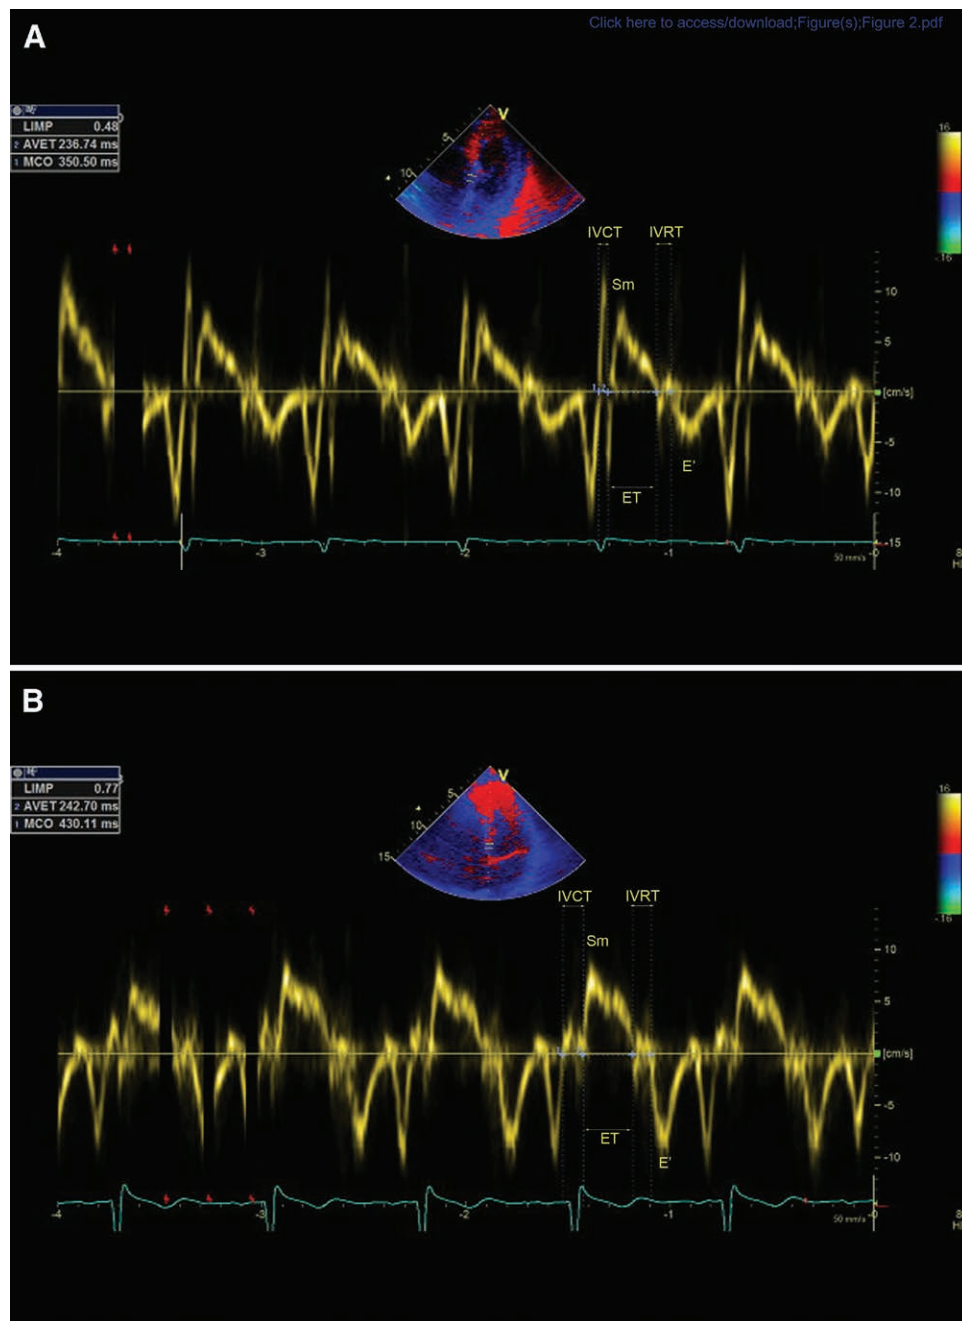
Left ventricular myocardial performance index in patient A, who received low tidal volume ventilation, and patient B, who received intermediate tidal volume ventilation. The myocardial performance index is obtained using tissue Doppler imaging with an almost parallel ultrasound beam positioned at the septal annulus. The isovolumetric contraction time (IVCT) and isovolumetric relaxation time (IVRT) have a longer duration in patient B compared to patient A with a similar ejection time (ET) resulting in a higher myocardial performance index as this is calculated by $(IVCT + IVRT) / ET$, indicating decreased myocardial function. When the aortic valve ejection time (AVET) and mitral valve closure-to-opening time (MCO) are selected, the EchoPAC software automatically calculates the left ventricular myocardial performance index which is denoted as LIMP in the top left corners. The systolic maximal velocity (Sm) and early diastolic maximal velocity (E') are also shown.
